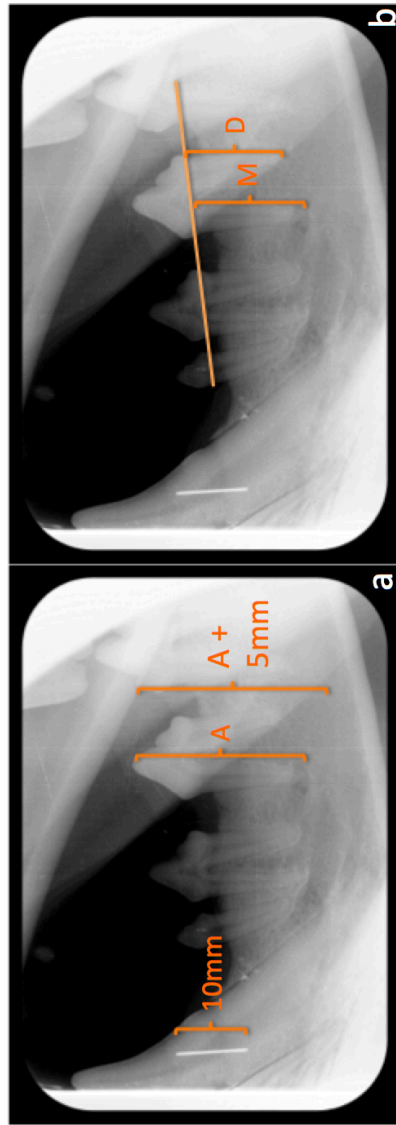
Radiographic measurements pre surgery. a) calibrated wire to 10mm, A is root length, A+ 5 mm is depth used to guide surgical cut b) reference line from CEJ of 1st premolar to furcation of 4th premolar to measure Mesial and Distal root length (same measurement also used post consolidation)
